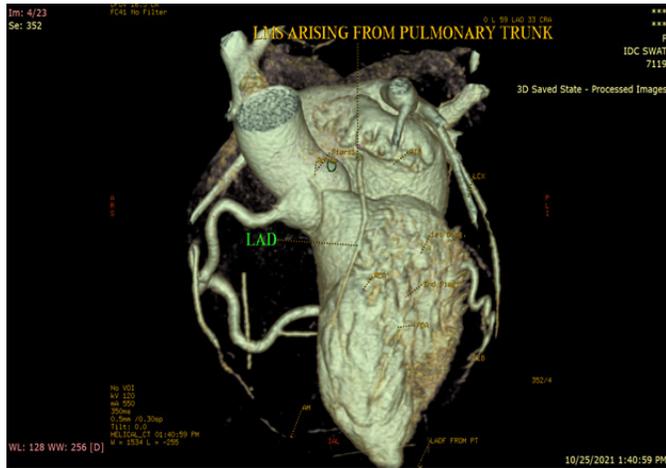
3 D Volume rendered CT coronary angiogram reconstructed image, showing left main stem arising from pulmonary trunk, suggestive of pulmonary artery-derived anomalous left coronary artery (ALCAPA)
